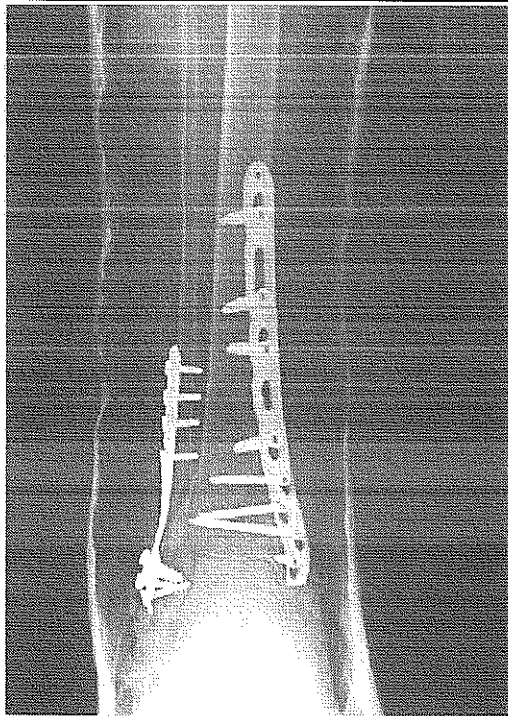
First X-ray control immediately after intervention.
